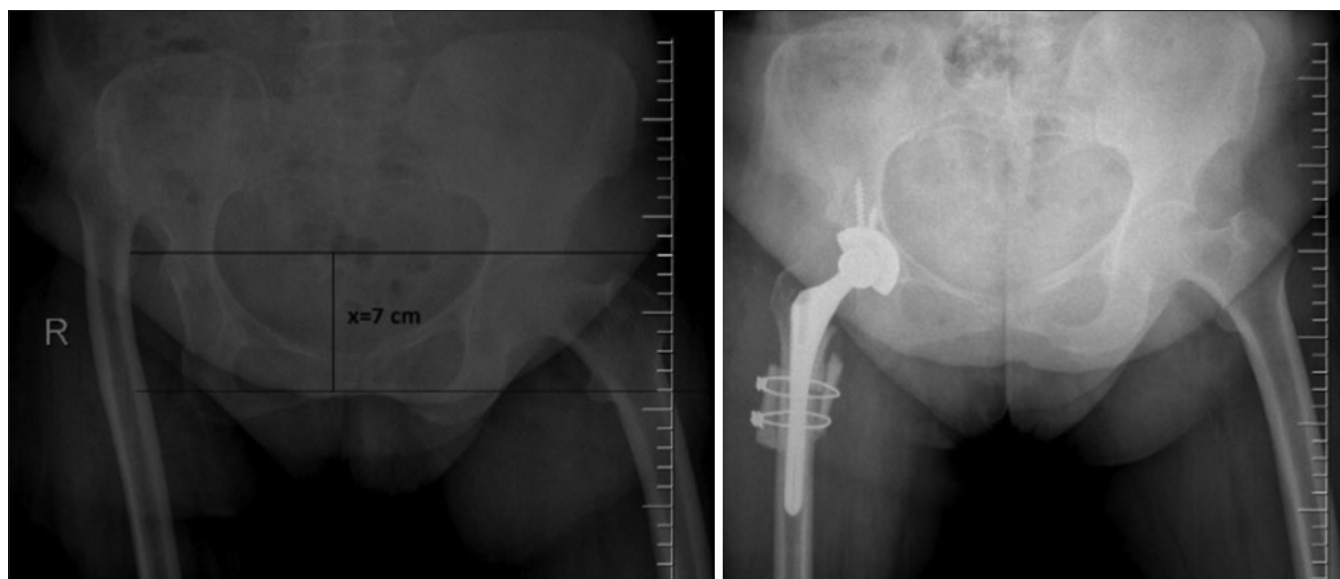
X-ray pelvis showing both hips anteroposterior view showing preoperative measurement of the resection and postoperative X-ray of the same patient
